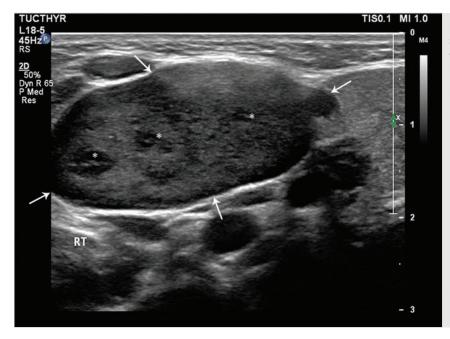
B-mode ultrasound image of the neck showing a lymph node (*arrows*) with loss of central hilum and presence of internal hypoechoic nodules (*asterisks*). The node measures around 2.5 × 1.5 cm. These findings indicate malignancy.
